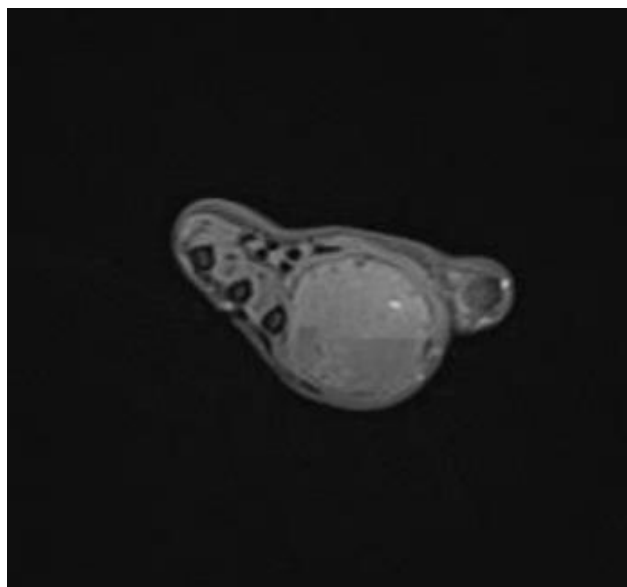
MRI of the right hand, axial proton density fat-suppressed image: extension of the lesion into the intermetacarpal space with mild displacement of the flexor tendons
